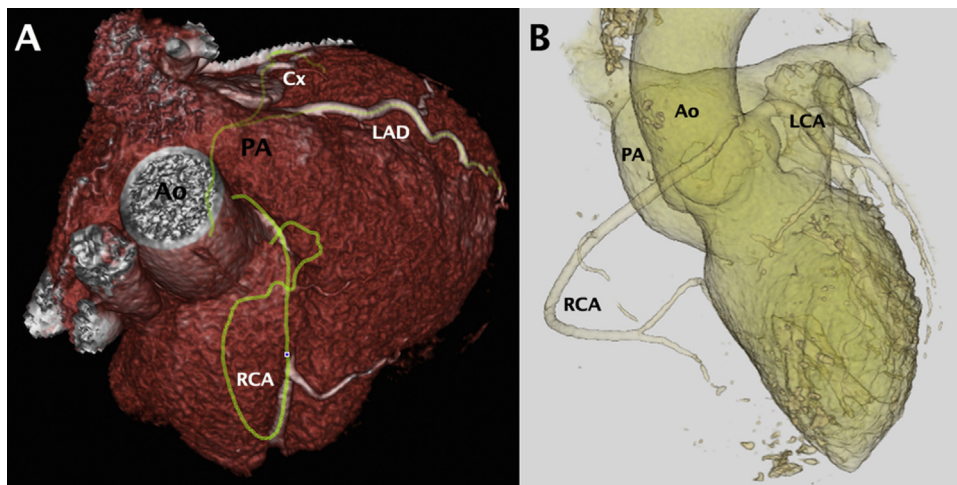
3D reconstruction of a Computed Tomography image showing an anomalous origin and course of the RCA.
